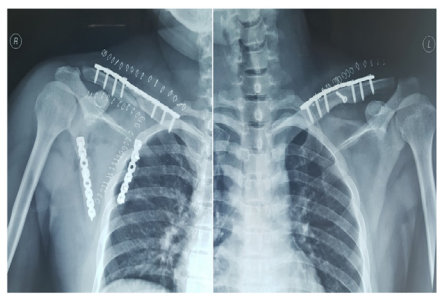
Immediate post-operative X-Ray showing the use of anatomical locking plates.
